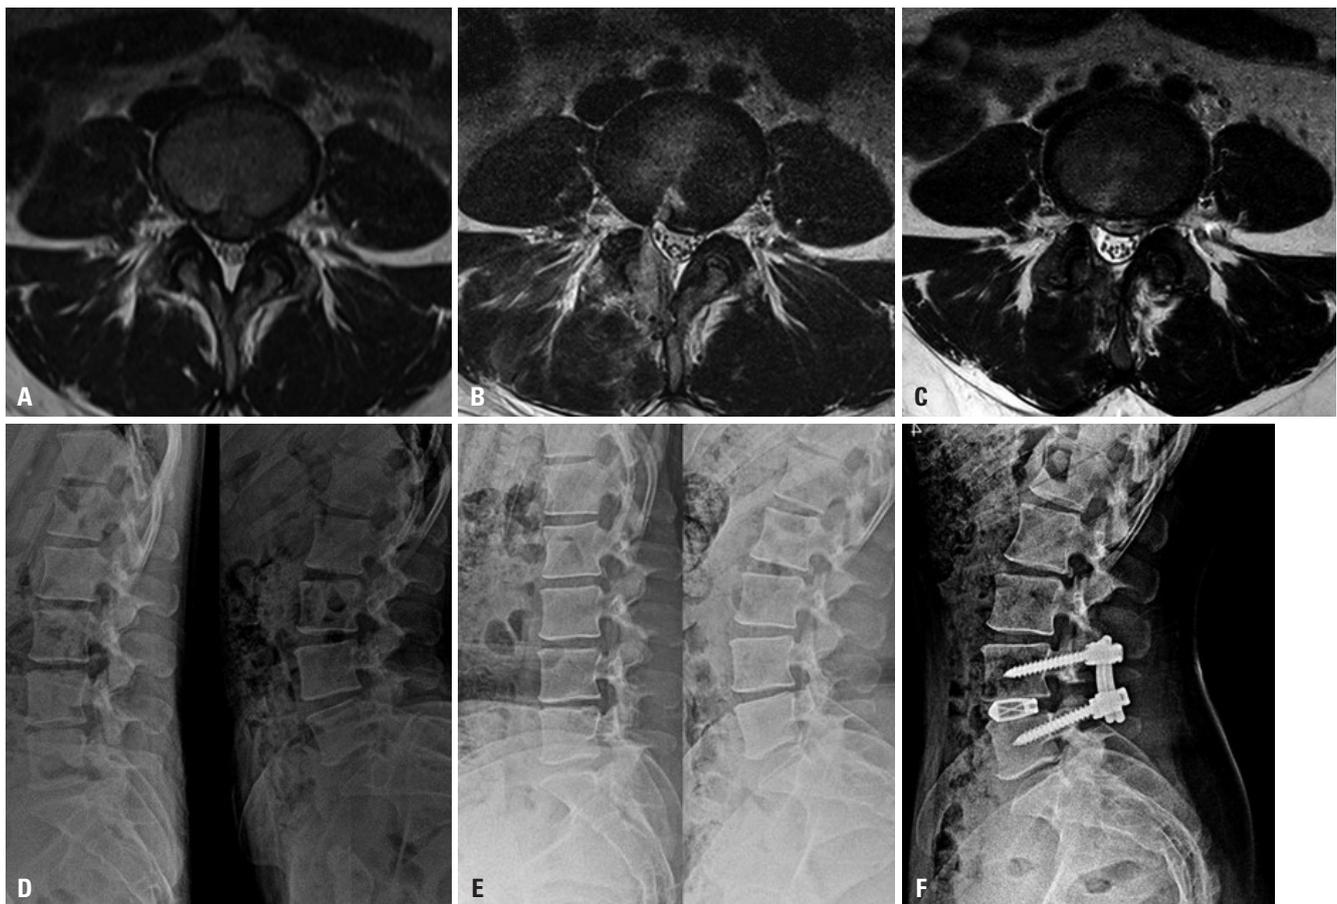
Postoperative instability and facet damage. A 33-year-old female patient experienced pain and numbness in her right leg due to a herniated lumbar disc at the L4–5 level. (A) Axial T2W MRI showed significant disc protrusion and subligamentous rupture at the L4–L5 level. (B) Axial T2W MRI obtained the day after UBE surgery showed decompression of the thecal sac. (C) Eight months after undergoing UBE, the patient complained of intense pain radiating to both legs and severe back pain when transitioning from sitting to standing, making walking difficult. MRI revealed re-herniation. (D) Initial lumbar spine flexion–extension radiographs. (E) The L4–5 space shows slight anterior collapse of the lumbar spine on a lateral flexion X-ray taken 8 months after surgery. (F) PLIF was performed at the L4–5 level, resulting in improvement of the patient’s leg pain after surgery. PLIF, posterior lumbar interbody fusion; T2W, T2-weighted; UBE, unilateral biportal endoscopic discectomy.
